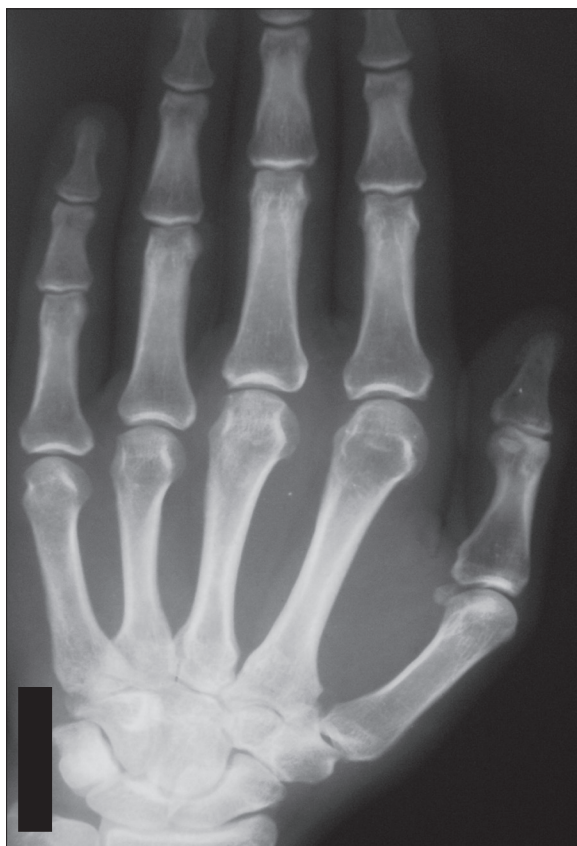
X-ray of a 36-old-male with a 4 month history of pain and soft tissue swelling in the neighbourhood of the 2nd and 3rd MCP joint. The patient has a twelve years history of psoriasis with no joint problem until now. The X-ray shows no other abnormalities, other than soft tissue edema.
